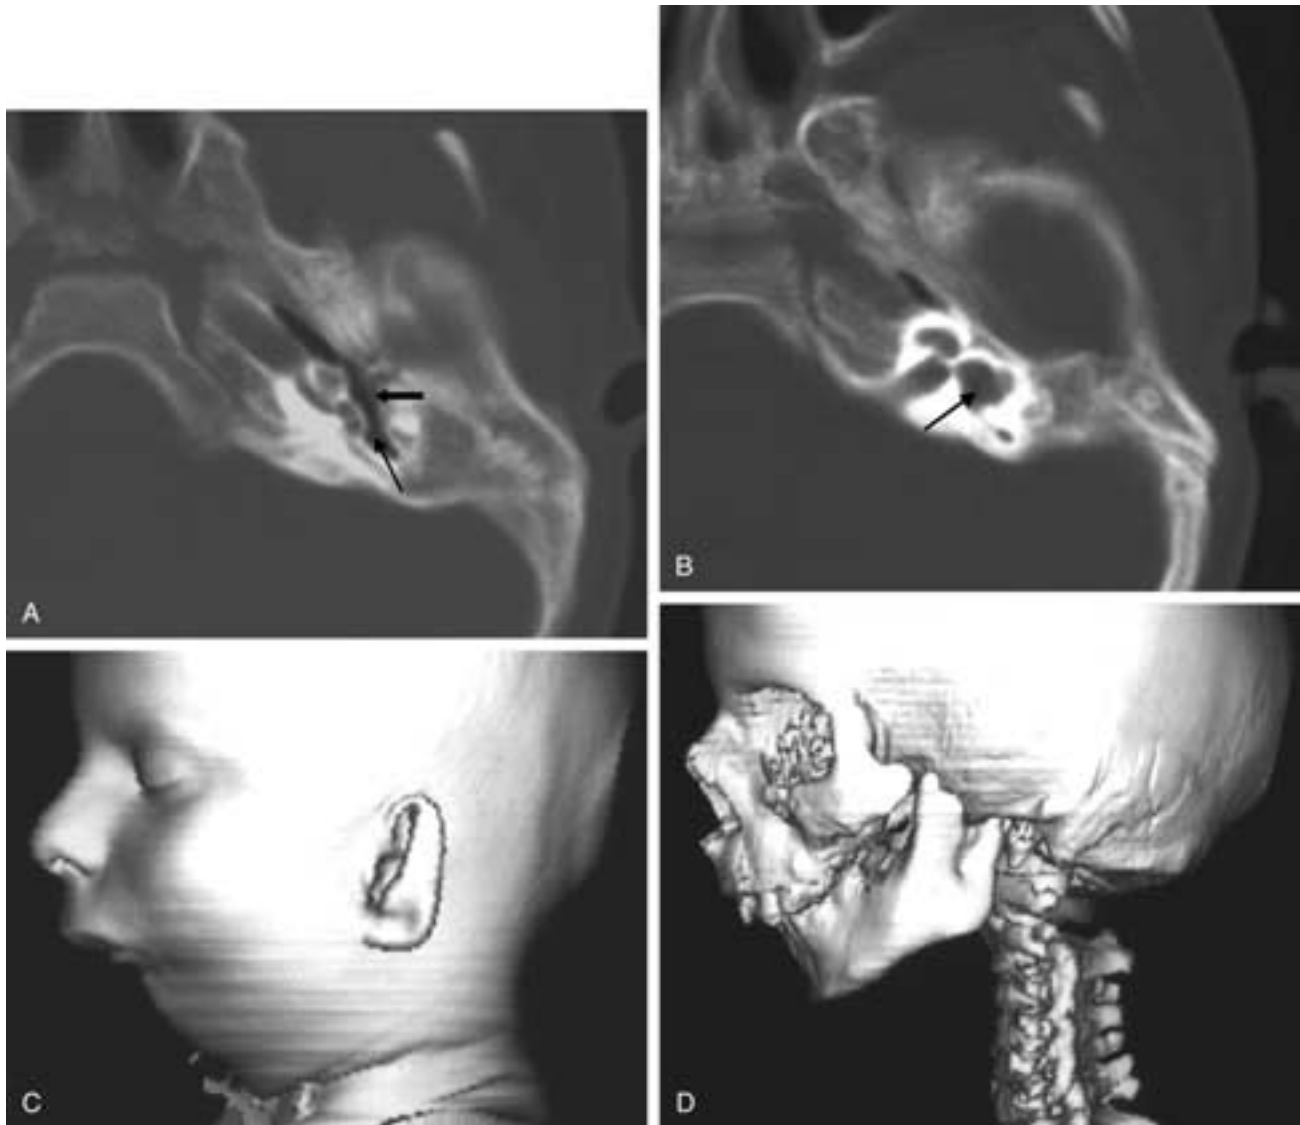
Treacher-Collins syndrome (mandibulo-facial dysostosis). A, Axial CT image showing atresia of the right EAC with a thick osseous atretic plate, a hypoplastic middle ear cavity (*thick black arrow*) and mastoids, and absence of the ossicular chain. Sinus tympani (*thin black arrow*). B, Axial CT image showing a dysplastic, enlarged vestibule (*black arrow*). C and D, Soft-tissue and bony 3D reconstructions showing a hypoplastic mandible and low-set ears, as well as malocclusion of the teeth and hypoplasia of the malar bones.
